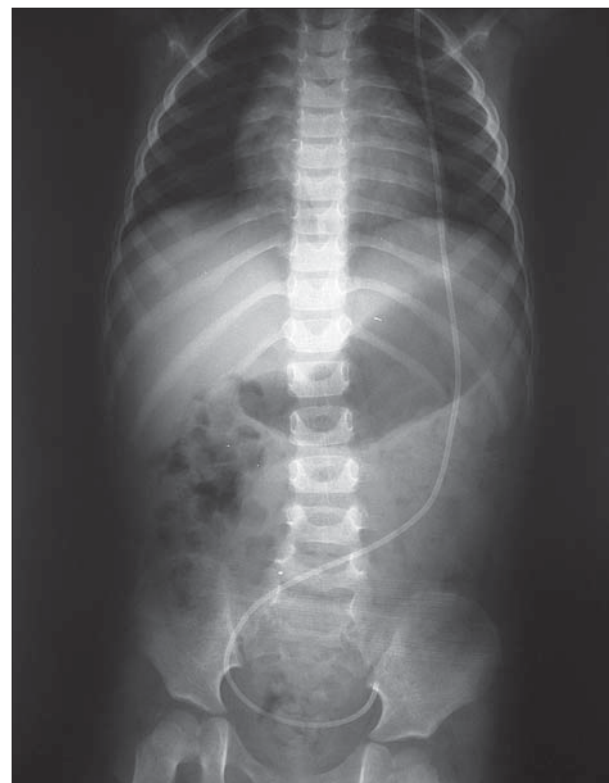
X-ray of the abdomen and pelvis with shadow of VP catheter in the urinary bladder
